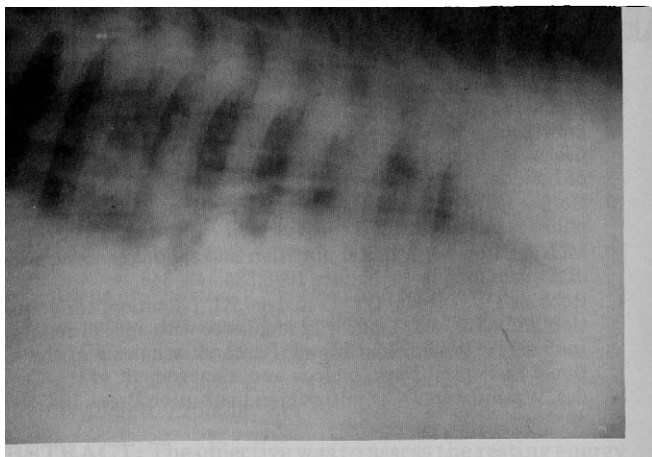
Ventral lung consolidation noted on chest roentgenogram.
